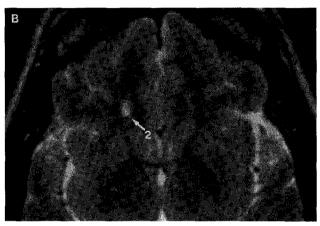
Axial T_2W MRI scans from a severely micrsomic (UPSIT = 20) 50-year-old man with an 8-year history of MS. The place of section in (A) is 6 mm below that of (B). Note the prominent plaques (10×5 mm each) within the posterior part of the white matter of the gyrus rectus of the L and R subfrontal lobe regions (arrows 1 and 2, respectively), and the relatively high signal intensity plaques in the subtemporal lobe regions (arrows 3 and 4).
